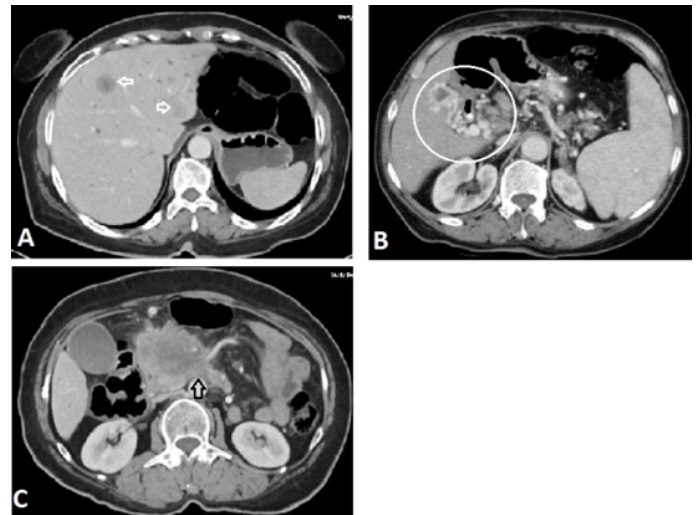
Axial contrast-enhanced computed tomography demonstrating patients considered inoperable with (A) hepatic metastasis, (B) vascular invasion resulting in cavernous transformation (in circle), and (C) duodenal invasion.
